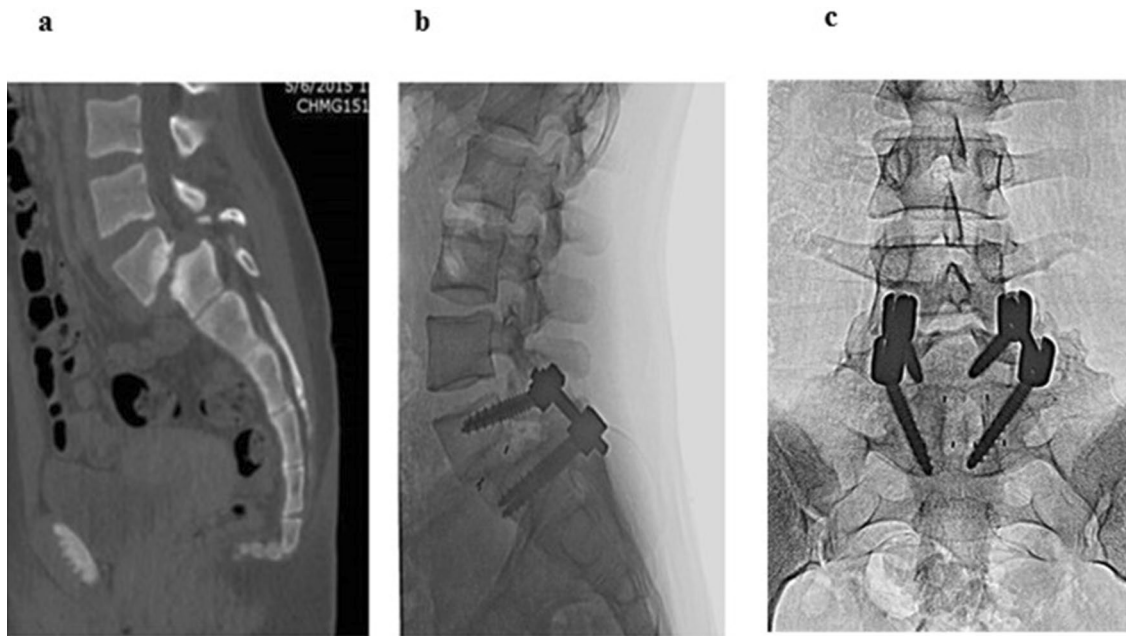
Preoperative mid-sagittal cut (a), 2-year postoperative lateral (b) and AP (c) radiographs for patient No. 5 (see Fig. 4)
